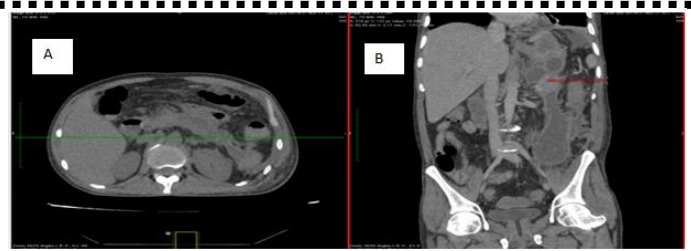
CT axial (A) unenhanced and Coronal (B) parenchymal phase shows walled off pancreatic necrosis.
